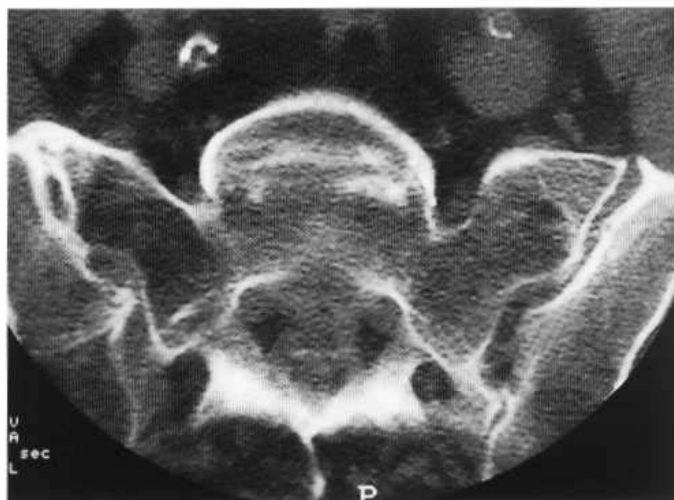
Diffuse idiopathic skeletal hyperostosis. The CT scan shows that the joint spaces are still patent but there is ankylosis anteriorly.
